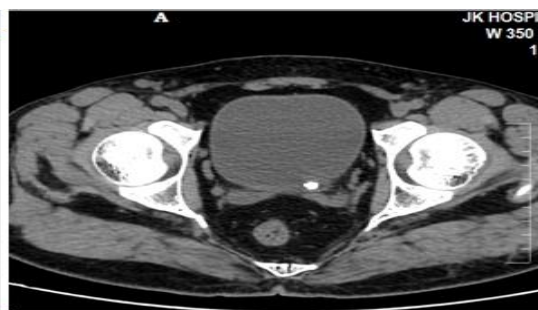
USG KUB of 45 year male showing an echogenic foci with PAS seen at left VUJ & CT axial of same patient showing hyperdense calculus at same location respectively. USG - slightly overestimate the size. (USG size -8.4 mm, NCCT size-7.8 mm)
